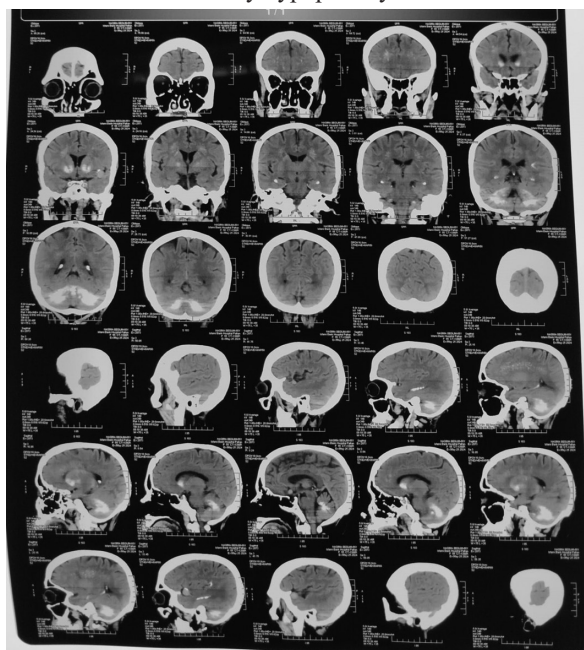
Coronal and Sagittal section of brain CT scan of patient showing calcifications in basal ganglia, thalami, cerebellum and corona radiata
